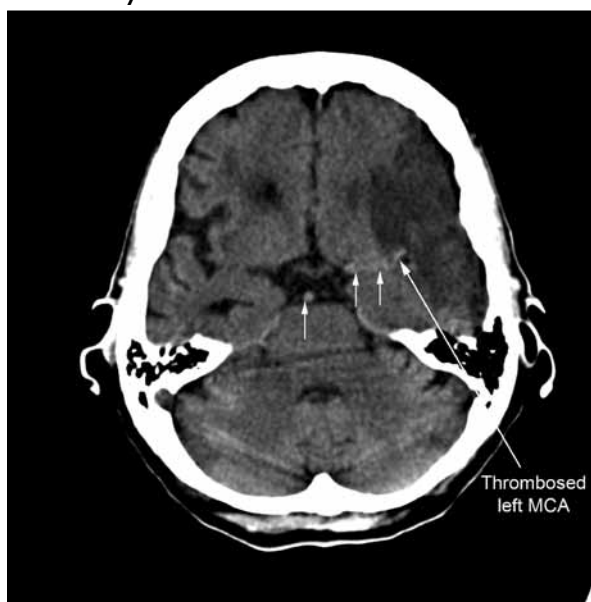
An unenhanced computed tomography scan with arrows demonstrating the 'dense artery sign' of an acute left middle cerebral artery thrombus.
